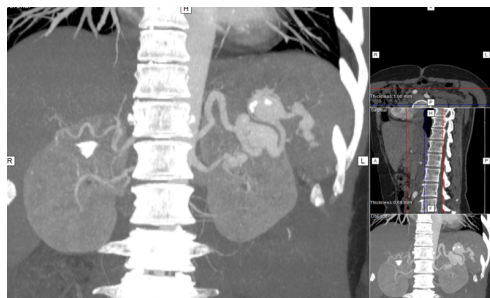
CTA demonstrating two aneurysms in splenic artery.
